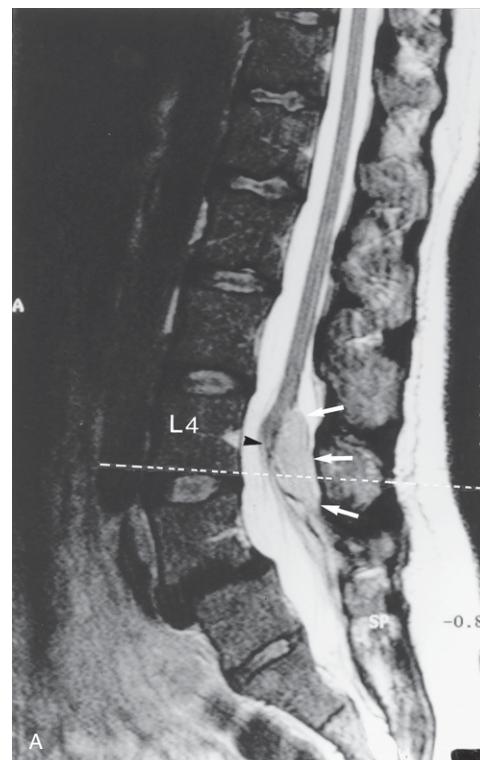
(A) MRI sagittal T2-weighted image showing the lipoma (white arrows) in the posterior part of the canal and the conus medullaris at the L4 level (arrowhead). The broken line shows the level at which the axial view was taken for (B). (B) MRI axial T2-weighted image through the area shown by the white broken line in (A). The arrow shows the lipoma. S = spinous process; L4 = 4th vertebral body endplate; R = right side of patient.
